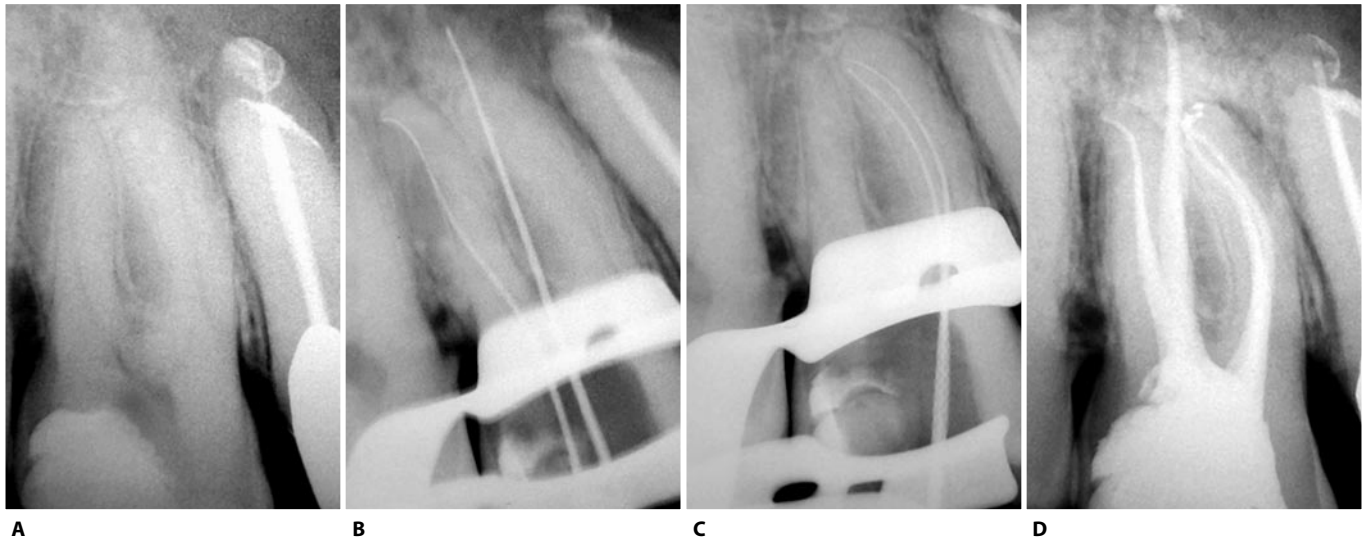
A. Canal treatment of an upper right first molar with curved (in the mesial root) and calcified canals. The choice of Thermafil has enabled the preparation to be limited to 25.06 in the buccal roots with a notable saving of time and dental tissue. B. Determination of working length in the distal and palatal canals. C. Determination of working length in the two mesial canals. D. Post-operative radiograph.
